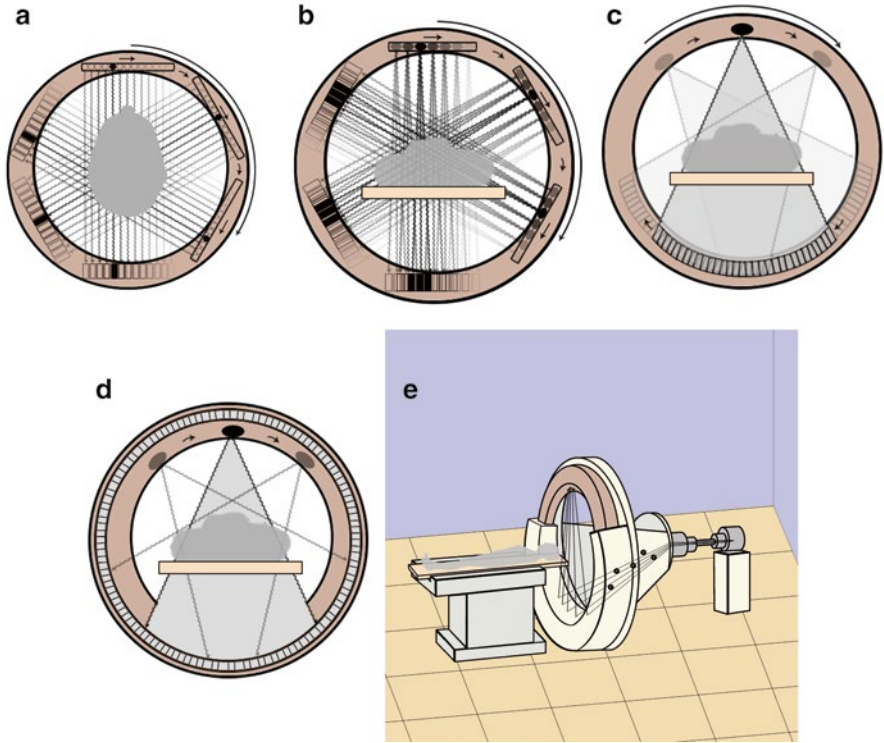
This picture shows the five generations of CT scanners. The third generation scanners are the most diffuse in clinical practice nowadays
